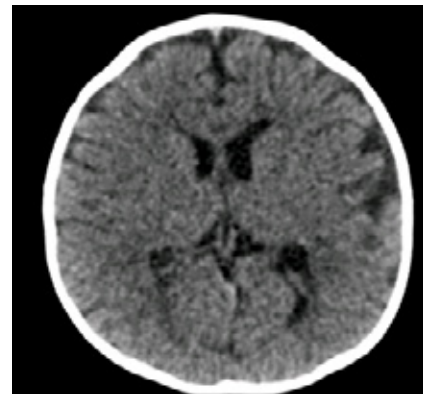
Preoperative head CT demonstrated mild trigonocephaly without evidence of hydrocephalus
